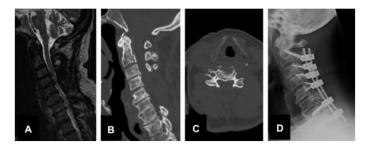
Pressure changes on the spinal cord in the MR image (A), condition after laminectomy in the CT image (B,C), X-ray, stabilization of the spine after laminectomy (D).
